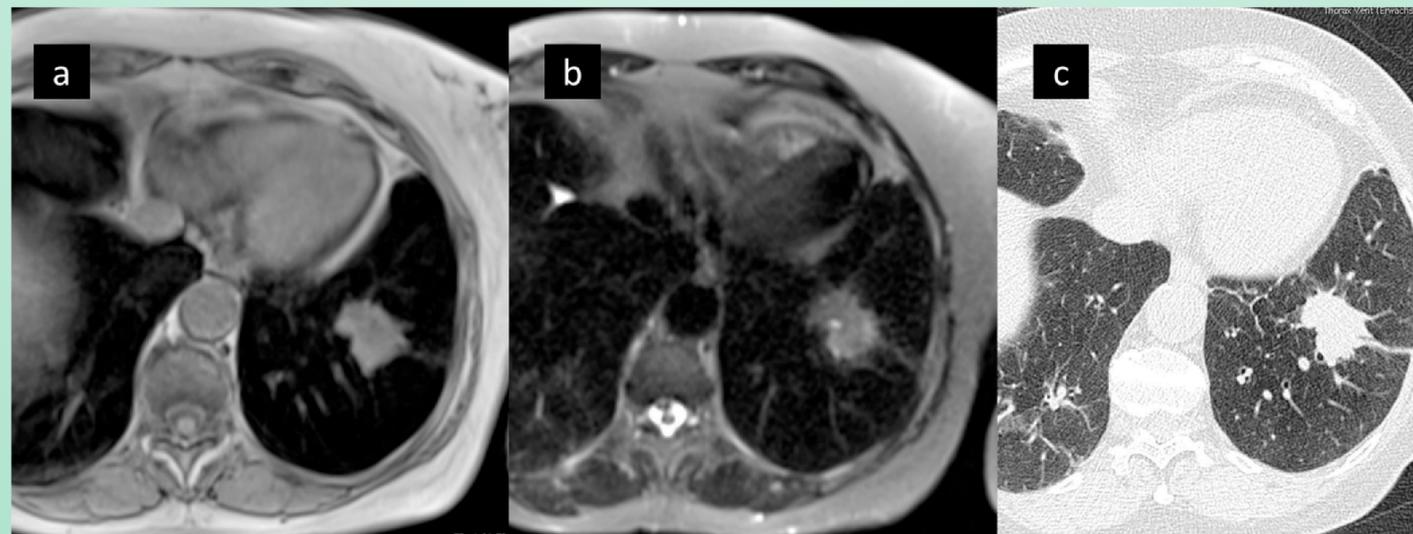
Lung cancer of the left lower lobe as an incidental finding in a 70 y old participant of a COPD imaging study. 3D-GRE (a), inversion recovery T2-half-Fourier-FSE (b) and LDCT-scans (c); 1.5 T MRI⁹
